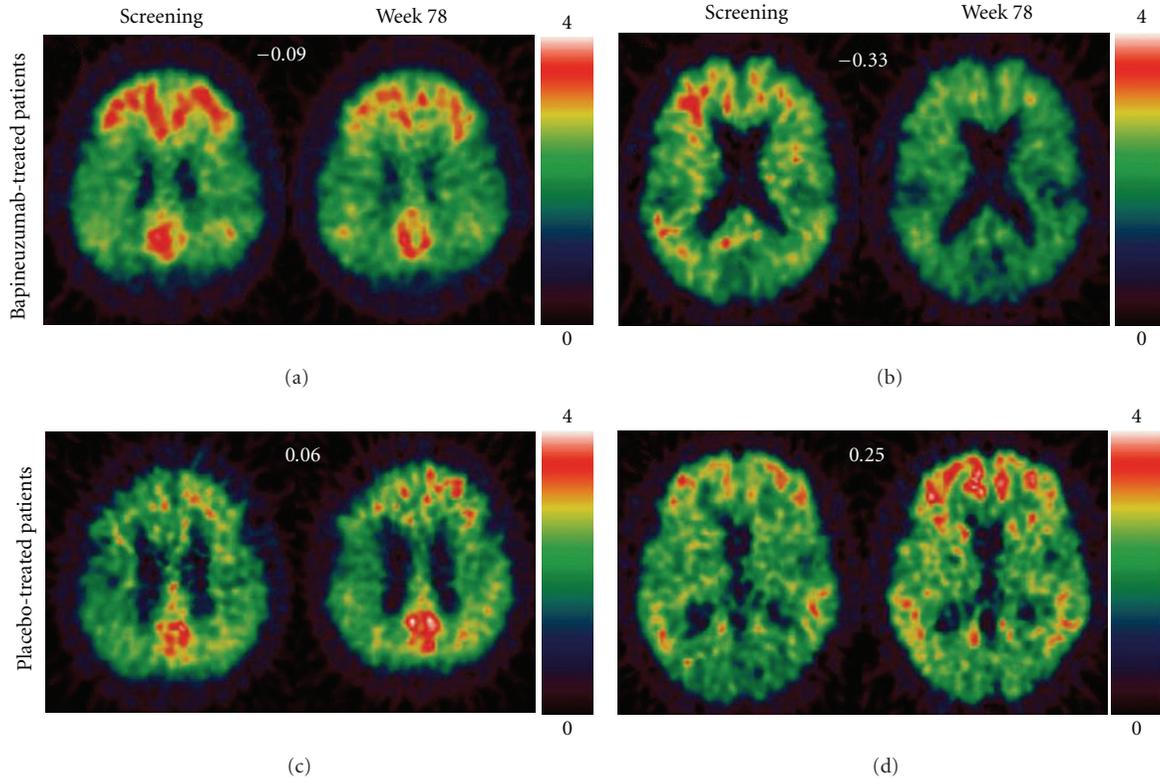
Positron emission tomography (PET) carbon-11-labelled Pittsburgh compound B (^{11}C -PiB) images from patients treated with bapineuzumab and those given placebo [57]. Reprinted from [57] with permission from Elsevier. Changes from screening to week 78 in patients treated with bapineuzumab (a, b) and in patients treated with placebo (c, d). Mean ^{11}C -PiB PET changes are shown at the top center of each panel for each patient. The scale bar shows the PiB uptake ratios relative to cerebellum by color. The scans before and after treatment are from MRI coregistered images in the same plane.
